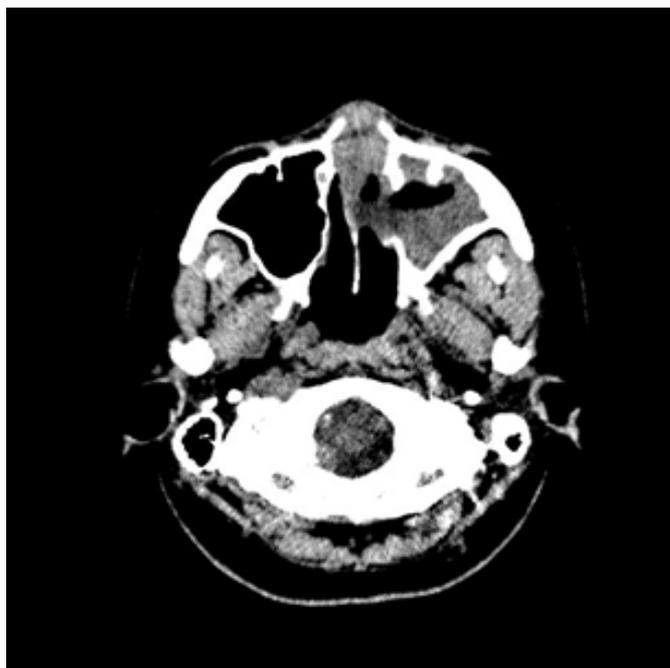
Computed tomography scan of para nasalsinuses showed nasal septal abscess (short arrow) with opacified left maxillary sinus and left medial wall defect (long arrow).
